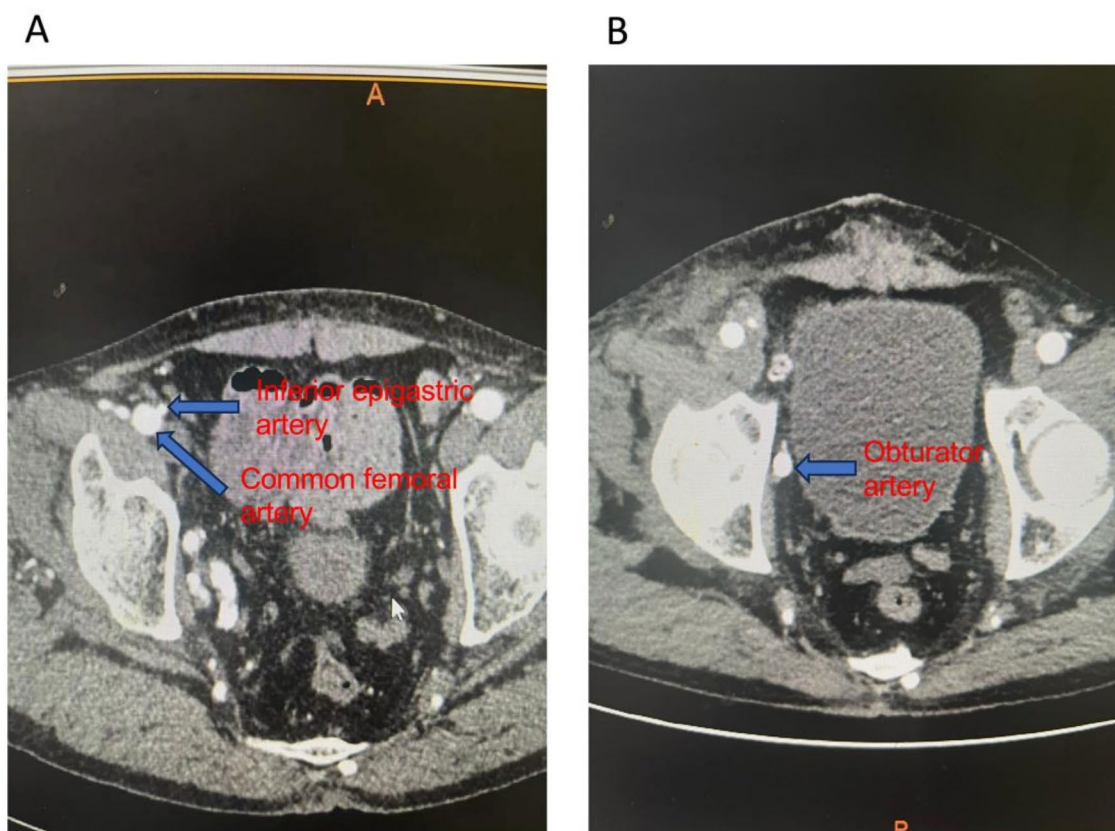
A. Preoperative CTA indicates communication with CFA and inferior epigastric artery. B. Preoperative CTA showed the obturator artery supplying blood to the deep femoral artery through Corona Mortis
